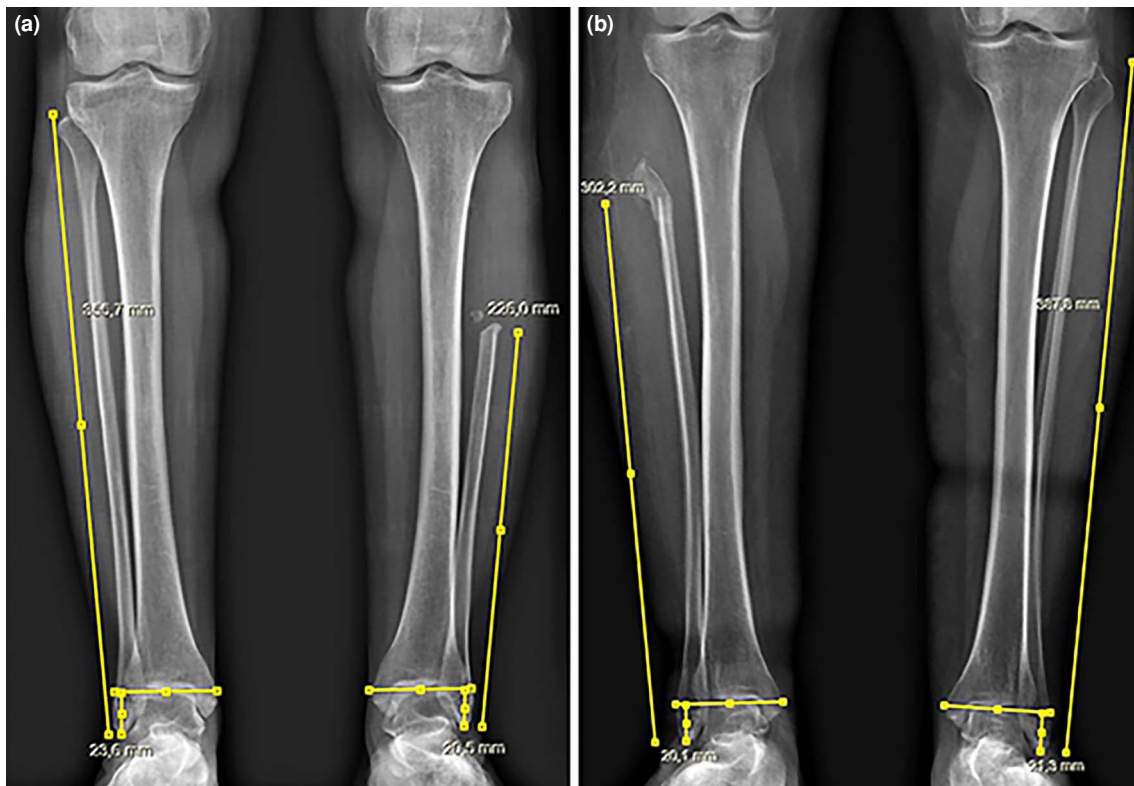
Postoperative radiograph examples of proximal fibula resection. (a) 37% resected fibula- 3.1 mm fibular length difference, (b) 22% resected fibula- 1.2 mm fibular length difference.
